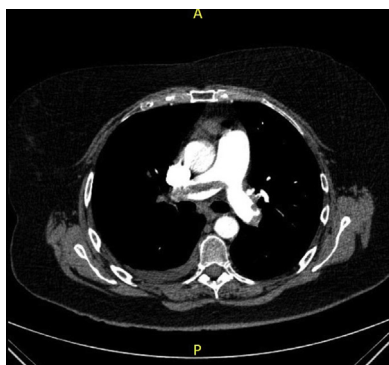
CT Pulmonary angiography shows extension of the saddle pulmonary embolism into the right pulmonary artery.
